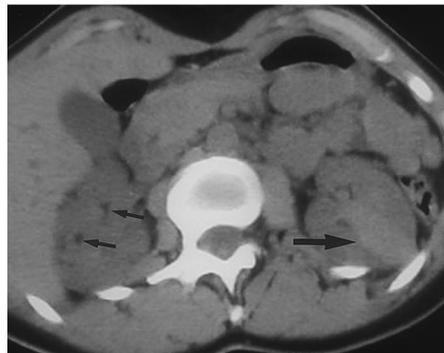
TS with AMLs in a 27-year-old woman. Transverse CT image demonstrates numerous bilateral AMLs (arrows). Facial angiofibromas were also present. Renal function was normal despite the number of lesions. Renal manifestations of TS include AMLs, cysts, and occasional renal cancers.
